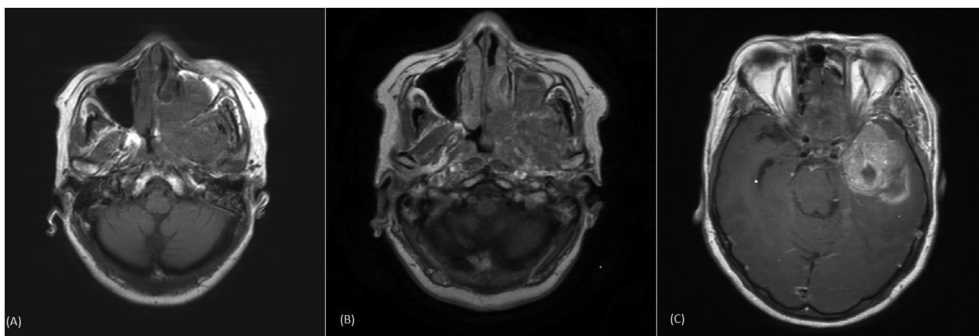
(A, B) Pre and post-contrast T1-weighted images showing heterogeneous enhancement of the lesion. (C) Post-contrast T1-weighted image showing invasion into the left middle cranial fossa causing mass effect onto the left temporal lobe. There is also an extension into the left carotid sinus with encasement of the intracanalicular part of the left optic nerve and the petrous part of the left internal carotid artery. Low signal intensity foci within the tumor in keeping with cystic changes.
